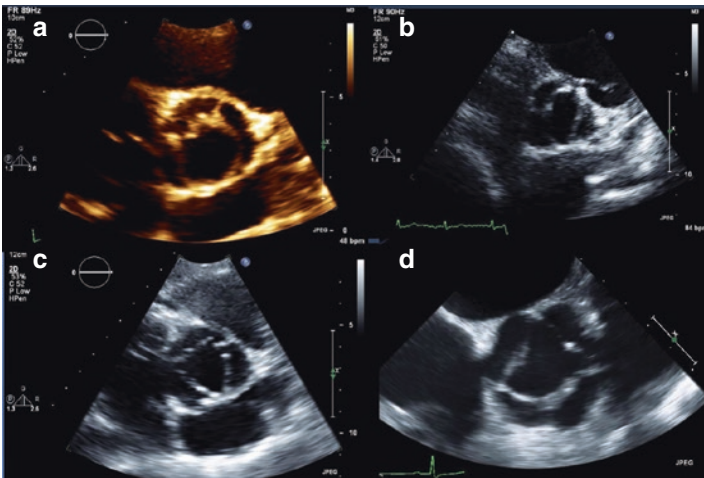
Echocardiographic short-axis images of the aortic valve. (a) Unicuspid aortic valve (note the open commissure between the left and the non-cusps). (b) Bicuspid aortic valve. (c) Tricuspid aortic valve. (d) Quadricuspid aortic valve
